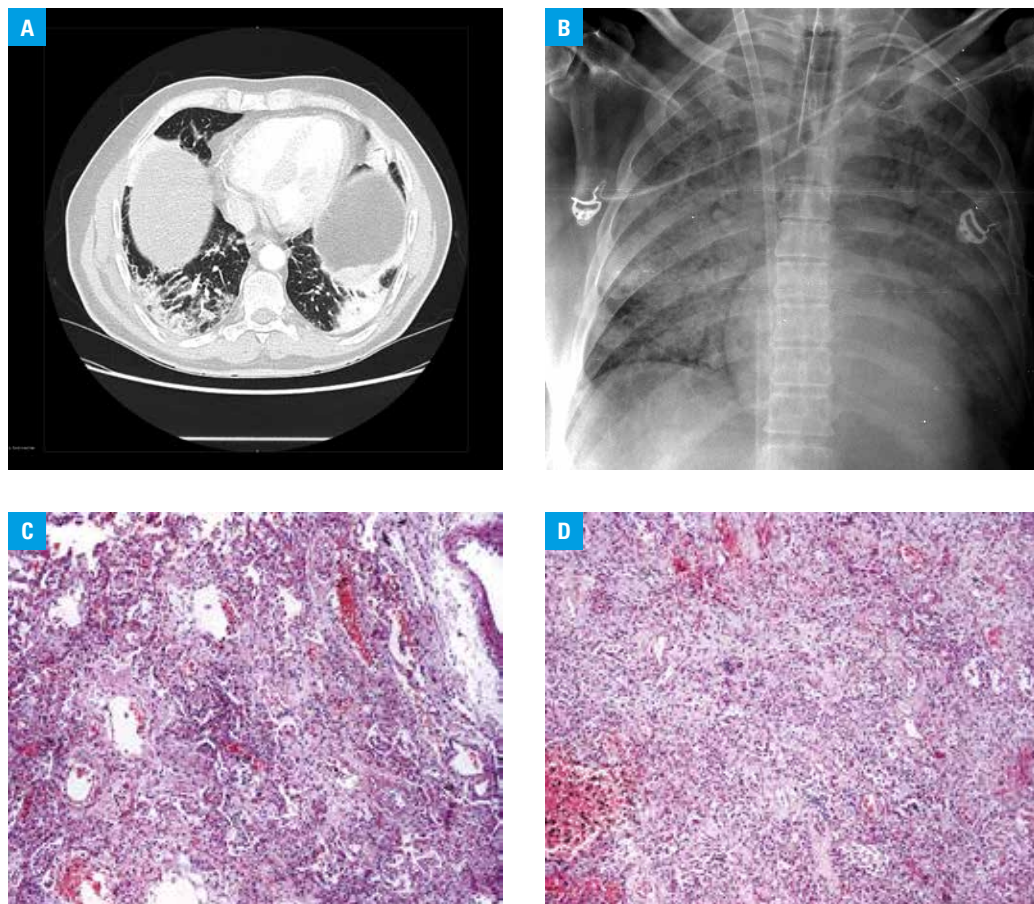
A – a lung computed tomography scan: bilateral patchy areas of consolidation and ground glass opacities limited to the lower lobes of the lungs; locally there are single accompanying nonseptal linear opacities; B – a chest X-ray: massive (apparent in all lung zones) bilateral areas of consolidation without obvious volume loss. An extracorporeal membrane oxygenation cannula is also visible; C – marked interstitial fibrosis: this pattern was seen in most of lung parenchyma; D – moderate lymphocytic lung infiltrate
